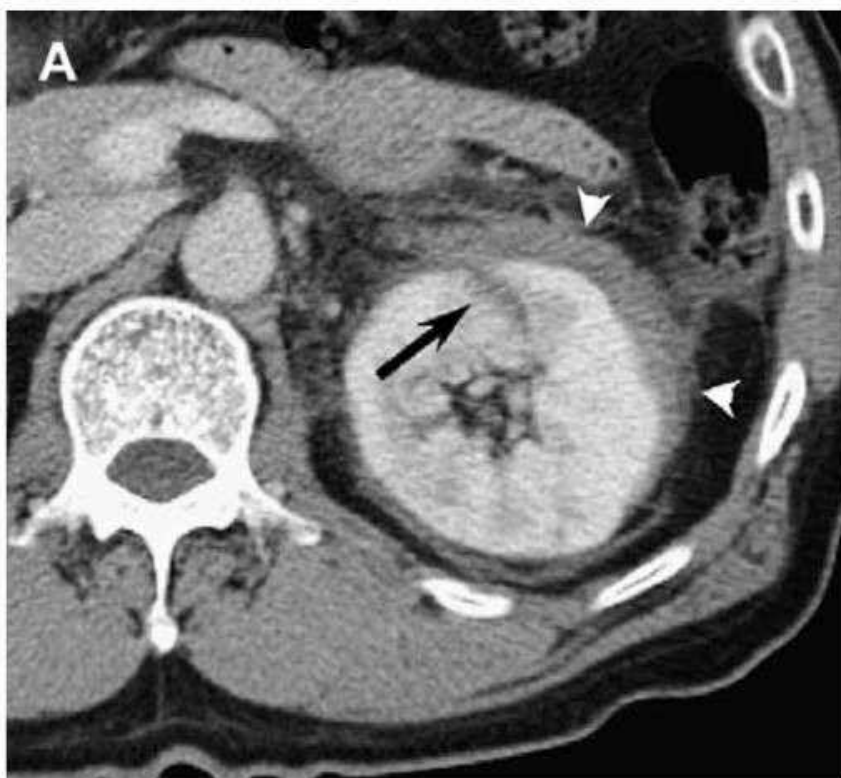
Grade 4 renal trauma on CT
